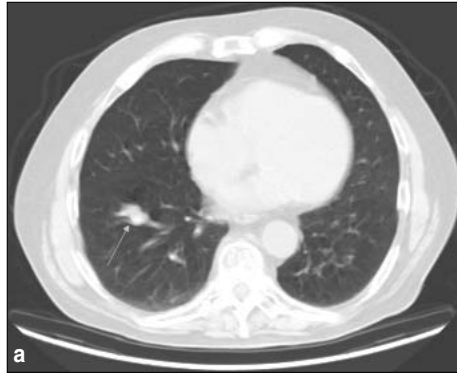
(a) CT shows a nodule in the right lower lobe of the lung (arrow). (b) The nodule is hypermetabolic on PET (arrow). Carcinoid tumor was confirmed after surgical resection.
